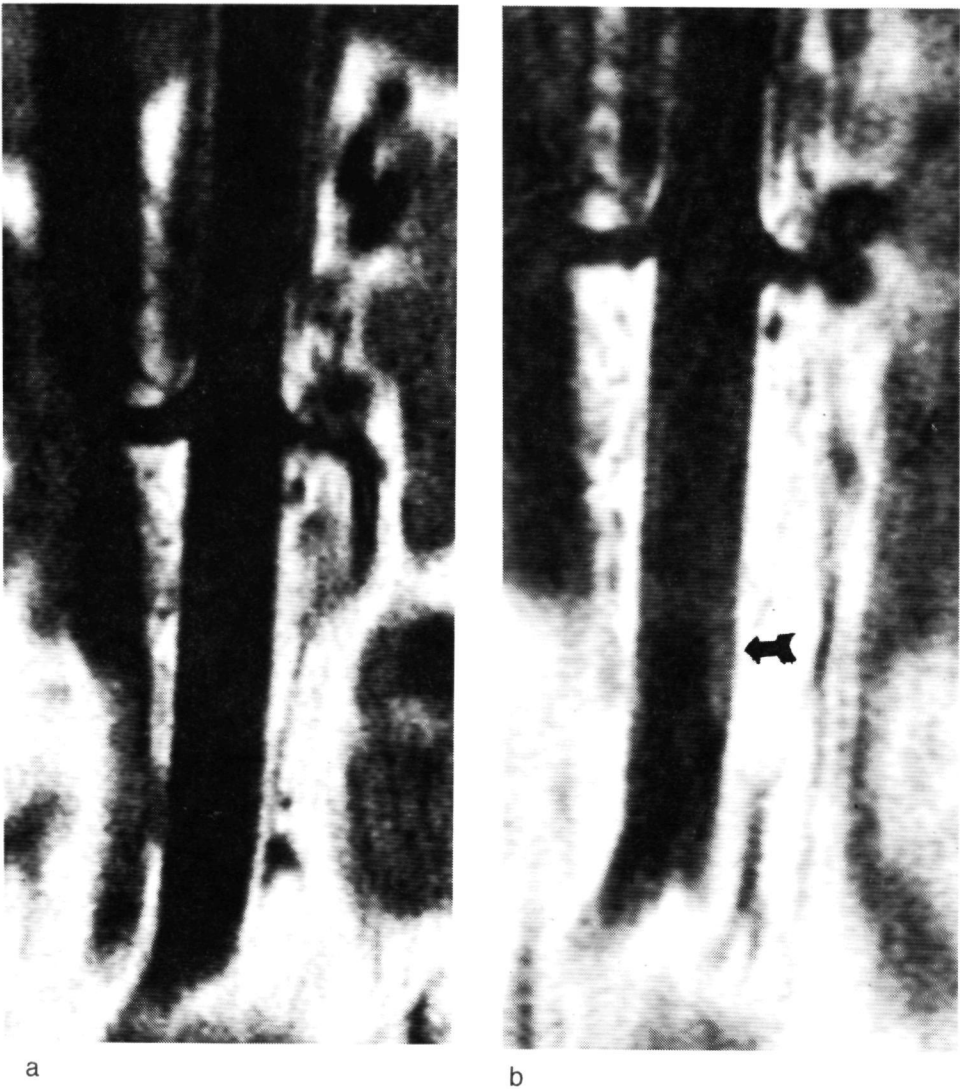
1b. A 40 year old patient showed no arteriosclerotic damages on the baseline MRI (Figure 13.1a). After two years of placebo-treatment (Figure 13.1b), an arteriosclerotic plaque was visual at the left side of the abdominal aorta.
